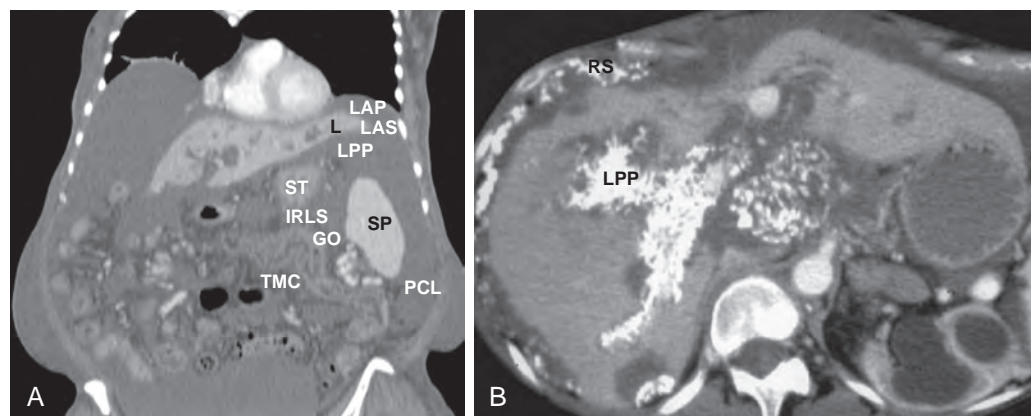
Left perihepatic spaces. A. Coronal reformatted image in a patient with ascites shows fluid surrounding the lateral segment of the liver (L) in the left anterior (LAP) and posterior (LPP) perihepatic spaces. Fluid in the left anterior subphrenic space (LAS) outlines the gastrocolic ligament, or greater omentum (GO). The left-most extension of the transverse mesocolon attaches to the left hemidiaphragm to form the phrenicocolic ligament (PCL), which forms an incomplete barrier between the supramesocolic and inframesocolic portions of the peritoneum. The stomach (ST) and inferior recess of the lesser sac (IRLS) are identified, as is the spleen (SP). B. CT section in a patient with widespread calcified mucinous tumor implants throughout the peritoneum shows the intrahepatic extent of the left posterior perihepatic space (LPP). Metastases occur over the diaphragmatic surface of the right lobe in the right subphrenic space (RS). Also noted is the transverse mesocolon.
